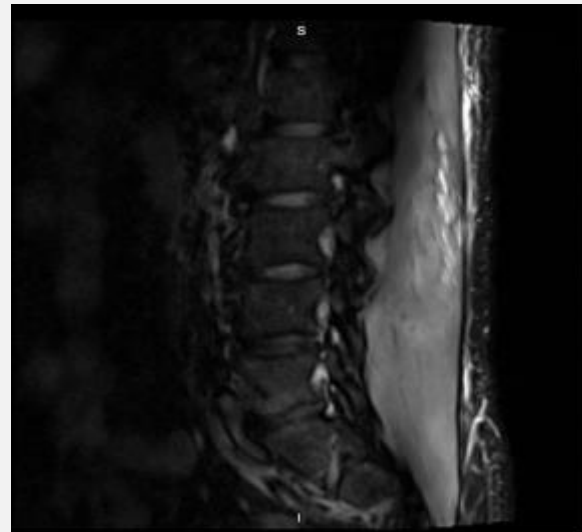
Lumbar spine's sagittal STIR MR image displaying severe paralumbar oedema
